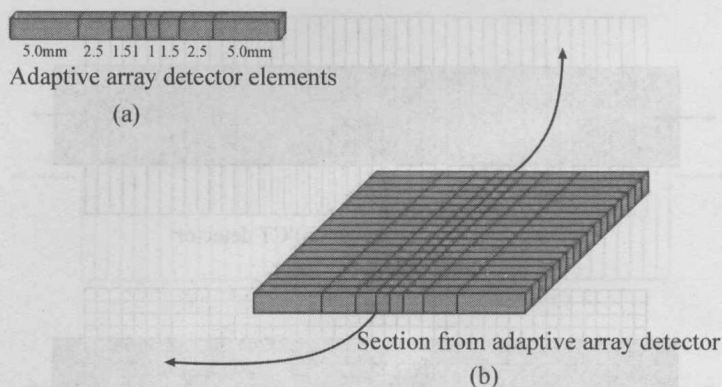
MSCT Adaptive array multislice CT detector. (a) Single column of elements. The 20 mm length of the single section CT detector has been divided into 8 non-equal segments of 1.0, 1.5, 2.5 and 5.0 mm each. (b) The columns of the adaptive array detector are packed together to form a curved 2D detector array
